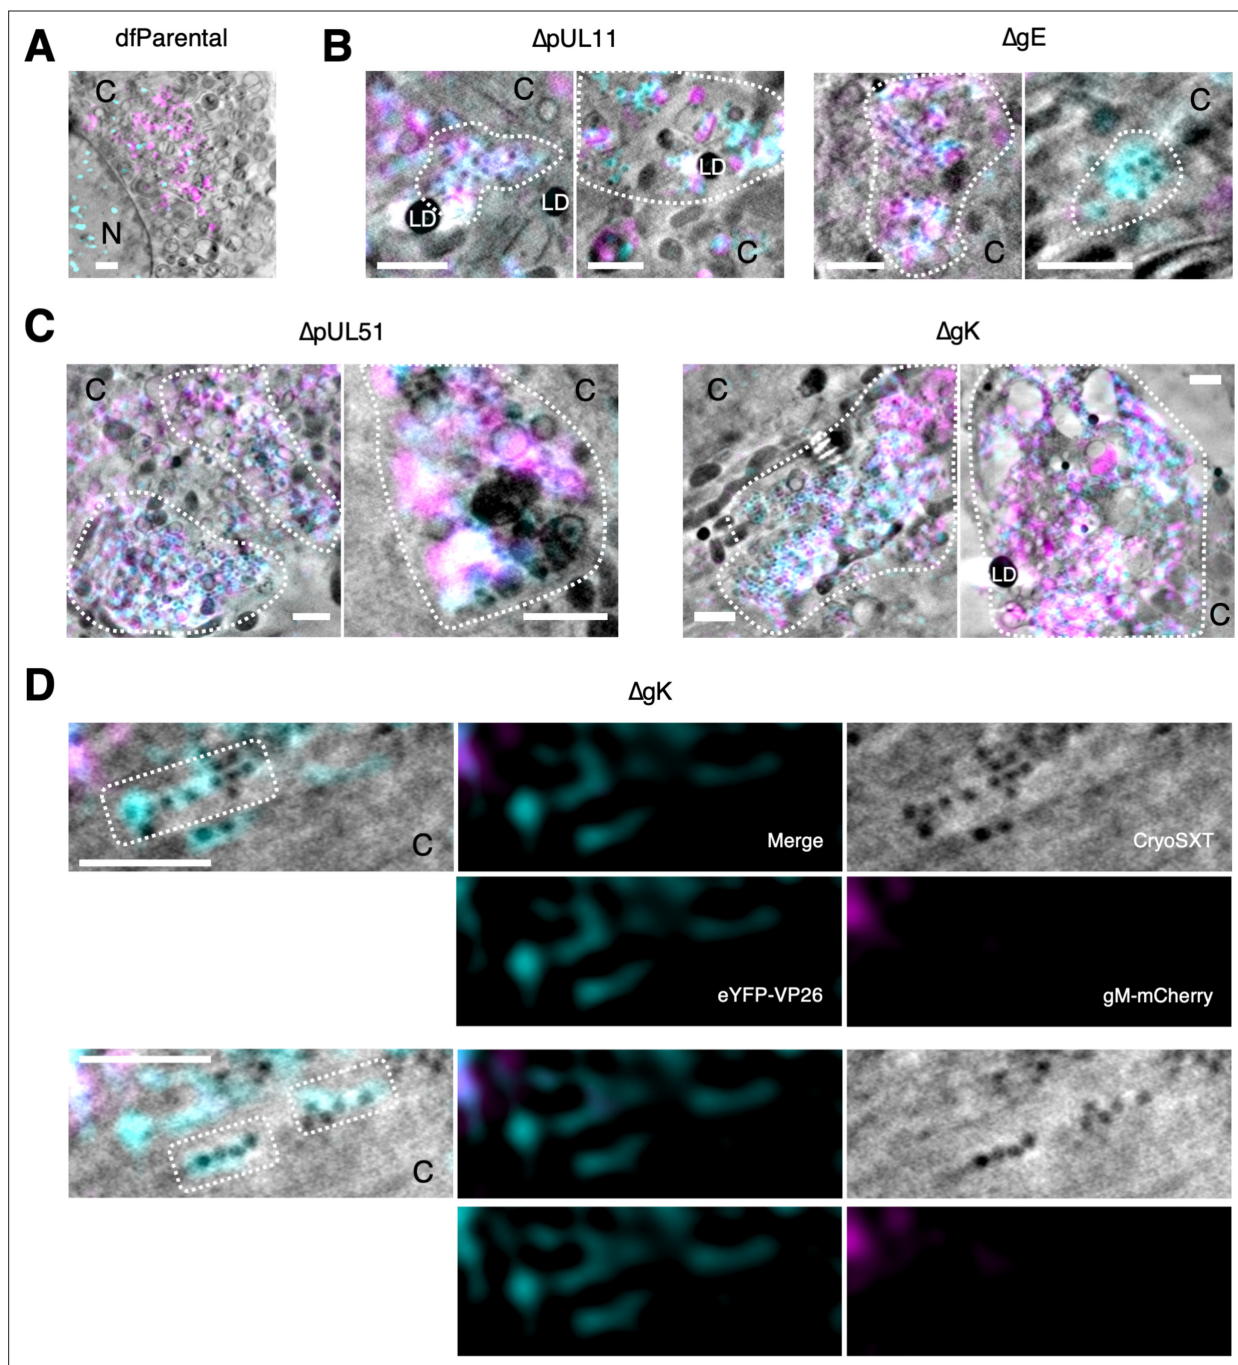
Correlative light X-ray tomography (CLXT) of cytoplasmic clusters of mutants. U2OS cells were infected at MOI = 2 with indicated viruses for 16 hr. (A) Individual envelopment events (arrows) as opposed to cytoplasmic clusters were observed for the dfParental virus. To aid visual comparison, this panel depicts the same data as shown in Figure 3C. C, cytoplasm; N, nucleus. (B) Cells infected with $\Delta pUL11$ or ΔgE viruses contained small clusters of capsids (outlined) in the juxtannuclear assembly compartment (JACs). (C) Cells infected with $\Delta pUL51$ or ΔgK viruses contained large clusters of capsids (outlined) in the JACs. (D) Linear arrays of eYFP-VP26⁺/gM-mCherry⁻ virus particles (outlined) were observed in the cytoplasm of a cell infected with ΔgK . Scale bars = 1 μ m.
